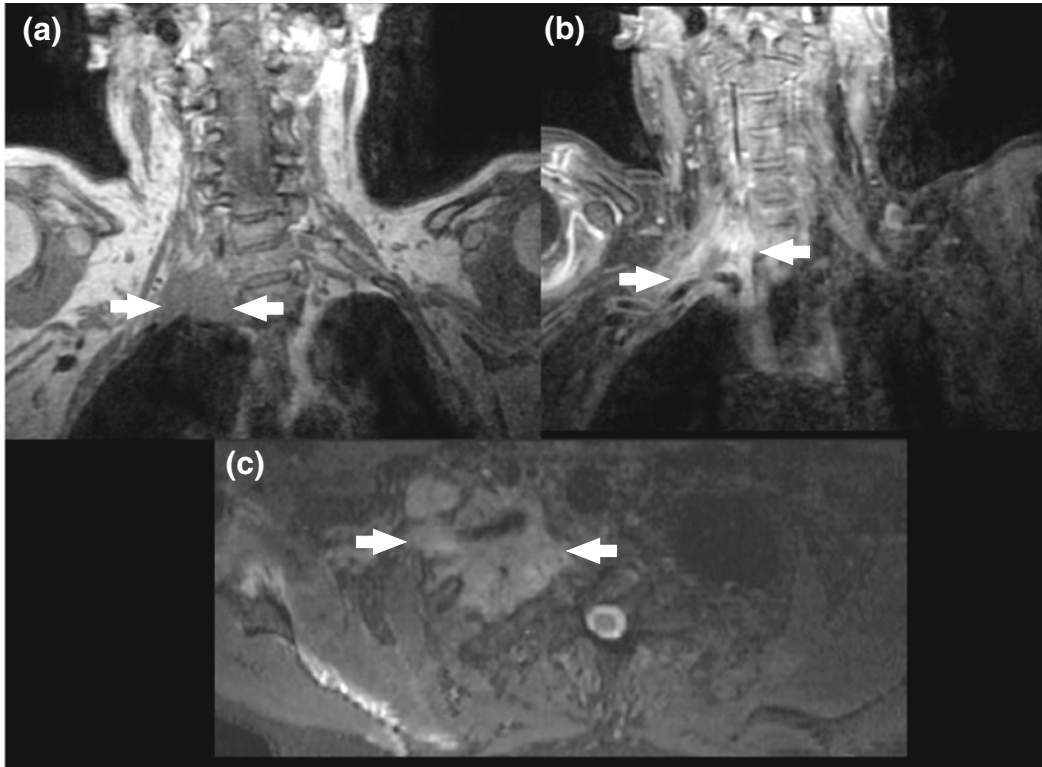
Pancoast tumor: brachial MR neurography in 65 year old man with Horner syndrome (ptosis, miosis and anhidrosis of the ipsilateral face), paresthesias and shoulder pain. Sequence 3D IDEAL coronal T1-weighted image (a), 3D IDEAL coronal FAT SAT T1-weighted image after contrast injection (b), 3D IDEAL coronal FAT SAT T2-weighted image (c), demonstrate a large
